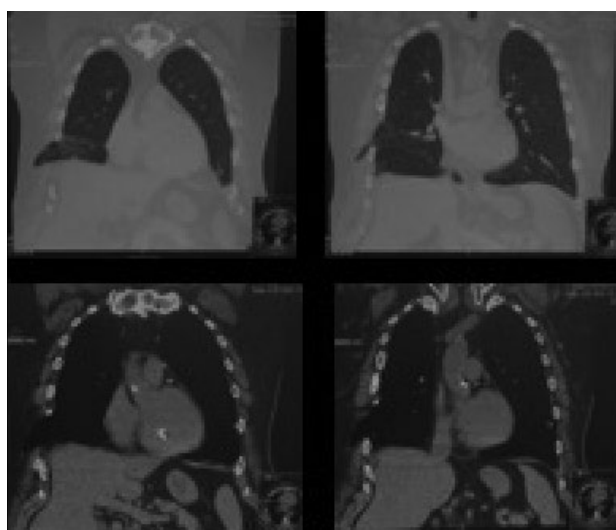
Coronary CT views of middle lobe hernia.
